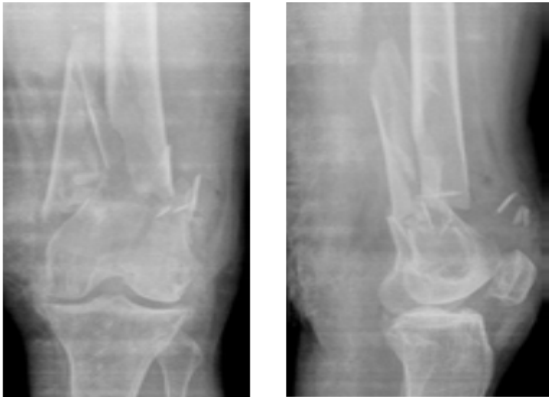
(A) and 1(B) :Antero posterior and Lateral radiograph showing AO type C3 distal Femur fracture.
